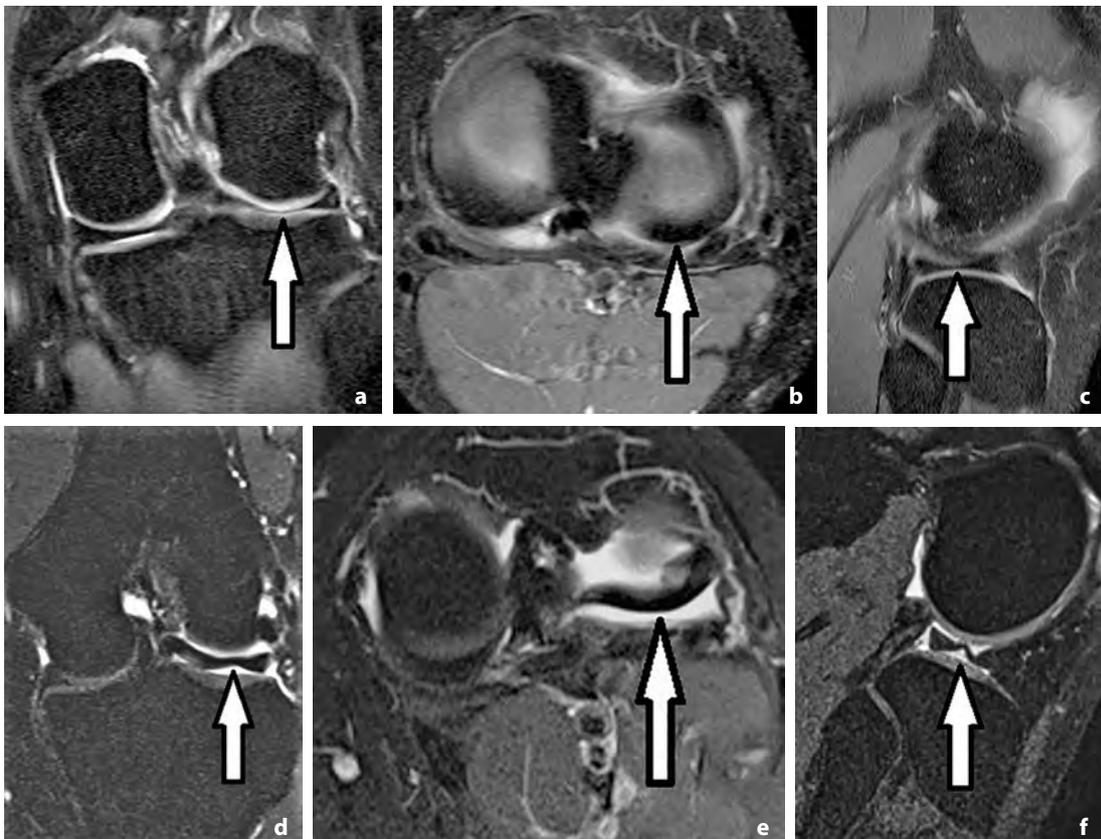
(a) Coronal (b) axial and (c) sagittal PD weighted FS MR images in the neutral position demonstrate a normal LM (arrows). (d) Coronal PD FS MR image in the provoked position demonstrates a 'flounce' in the LM (arrow). (e) Axial PD FS MR image in provoked position demonstrates anterior subluxation of the posterior horn of the LM (arrow). (f) Sagittal gradient echo MR image demonstrates anterior subluxation of the posterior horn of the LM with a 'flounce' (arrow). This image also demonstrates the absence of the PMFs
